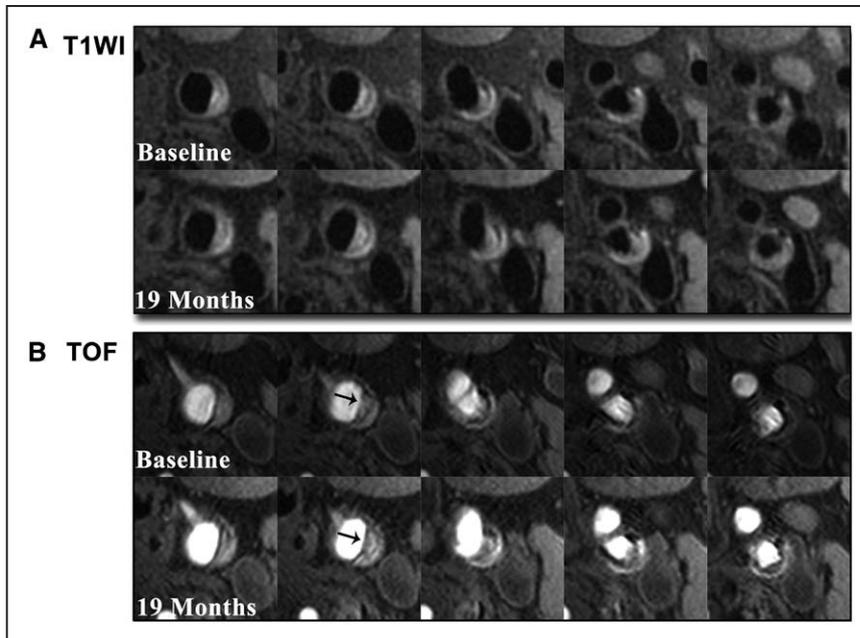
A 62-year-old female patient with carotid plaque progression after 19 months experienced a recurrence of ipsilateral stroke 17 months later since the second MR scan. A high-risk plaque at left carotid bifurcation was depicted on T1-weighted (T1W; A) and time-of-flight (TOF; B) images in both baseline and follow-up MR imaging. The baseline MR images showed that the carotid plaque had calcification, lipid-rich necrotic core, intraplaque hemorrhage, and fibrous cap rupture (black arrows). On the images of second MR scan, progression in plaque size can be seen.
